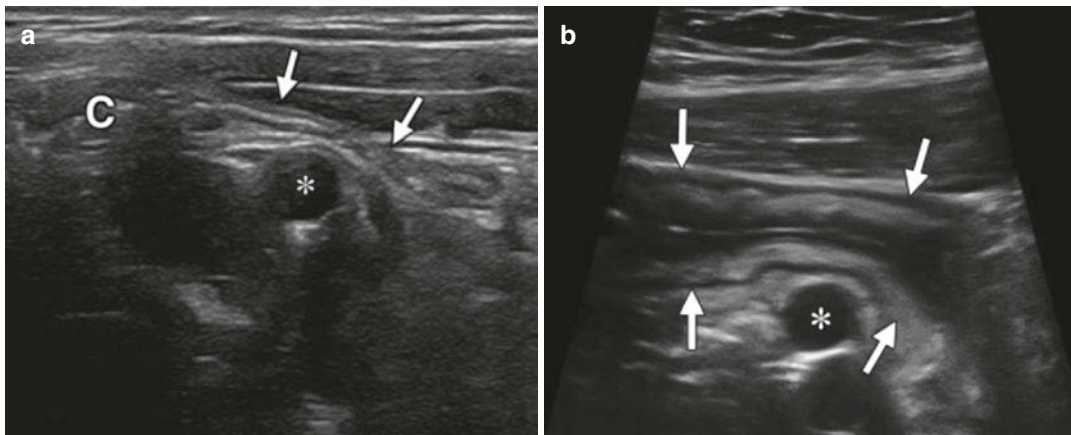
Ultrasound. The images show ultrasound imaging of the ileum of a healthy individual (a) and a patient with Crohn's disease (b). In a healthy individual
